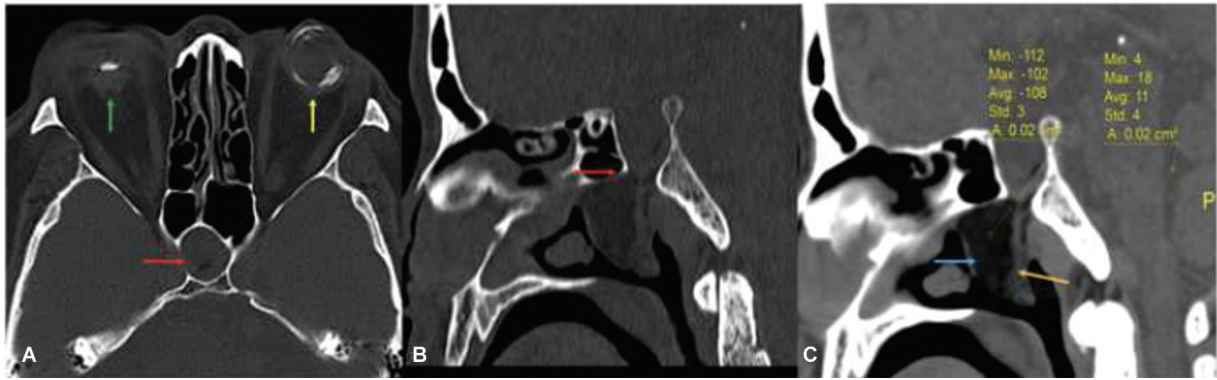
Persistent craniopharyngeal canal type 3C computed tomography (CT): Axial (A) and sagittal (B) reconstructions of the bone window of head noncontrast CT (NCCT). An oval-shaped defect (red arrow, A) is seen in the sphenoid body at the sellar floor, measuring 11 mm in anteroposterior (AP) diameter. Widened sella is seen, communicating with the nasopharynx (red arrow, B). Bilateral globes show calcification (yellow arrow, green arrow), with phthisis bulbi of the right eye (green arrow). A well-defined, fat-density mass lesion (blue arrow, C) is seen in the nasopharynx (-108 Hounsfield units [HU]) along with soft tissue density on the posterior aspect (orange arrow, C), consistent with dermoid.
